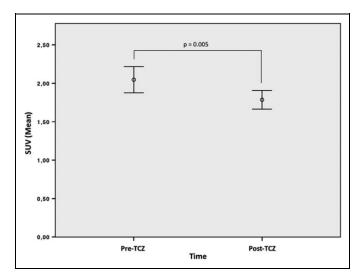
The reduction in the overall SUV after therapy with tocilizumab, which indicates a significant reduction in the FDG-PET-detected vessel wall inflammation. FDG-PET indicates ¹⁸F-fluorodeoxyglucose positron emission tomography; SUV, standard uptake value.
